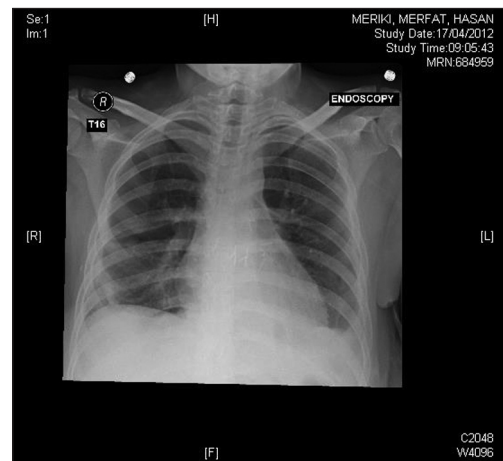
Chest X-ray after the removal of chest tubes post-pleurodesis
